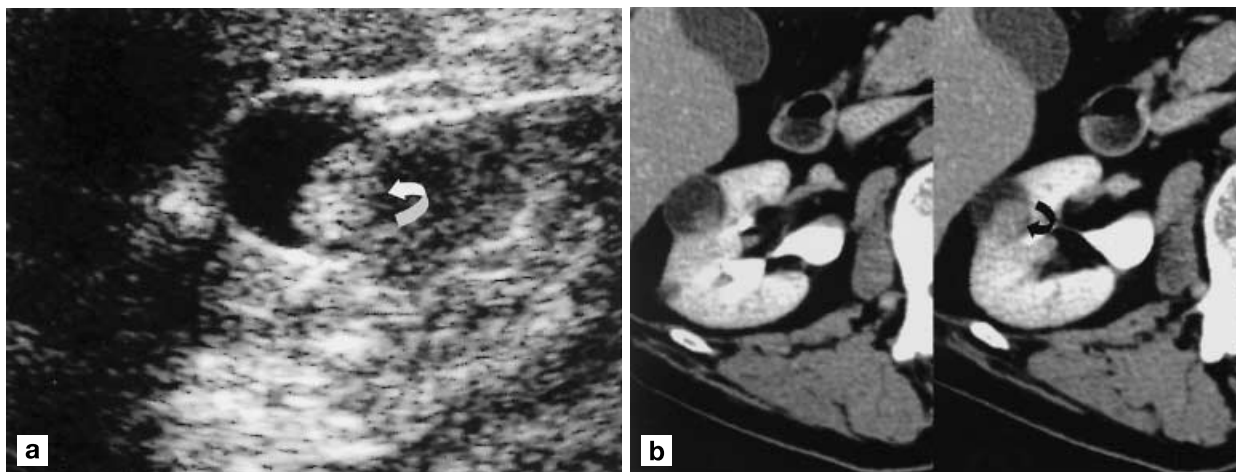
Cystic RCC. a Ultrasound shows a cystic renal mass with solid mural nodule (*curved arrow*). b A CT confirmation of a typical cystic RCC with contrast-enhanced tumor tissue component (*curved arrow*)
